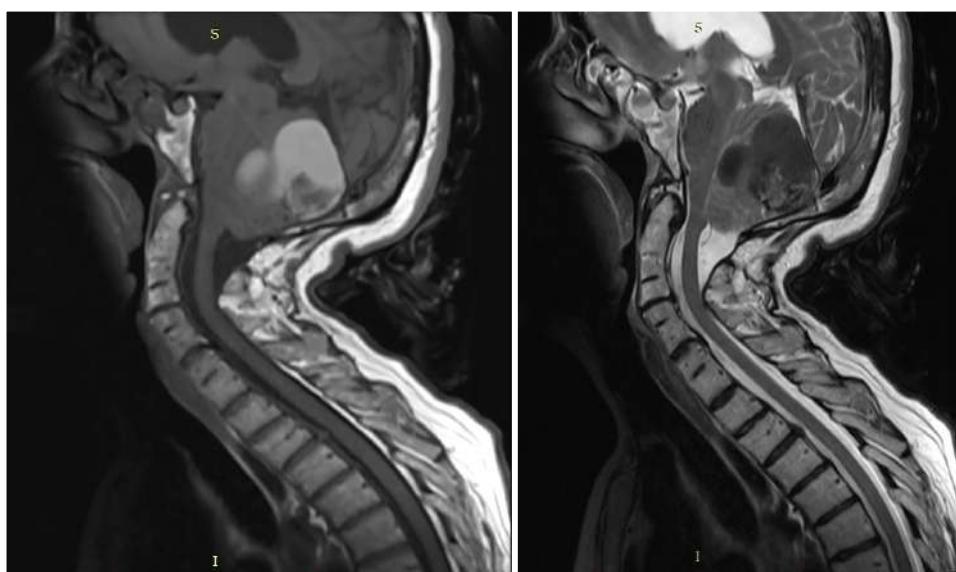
sagittal T1 and T2 MRI cervical spine shows fusion of cervical vertebrae consistent with Klippel-Feil syndrome.
